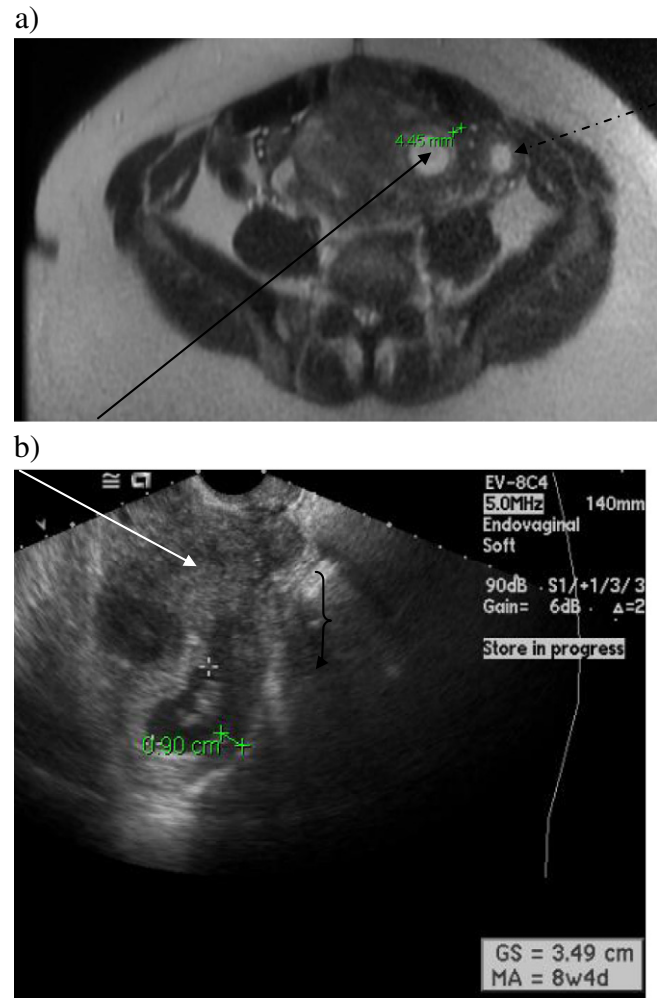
A 39-year-old pregnant woman with uterine leiomyomas presents with left lower quadrant pain to our institution. Two early first-trimester USs (not shown) were considered unremarkable in terms of gestation sac location, possibly due to limitations of the presence of multiple uterine leiomyomas. (a) MRI obtained at 7 weeks 0 days due to persistent pain (axial single-shot fast spin-echo image shown here with TR 2800, TE 87.12, flip 90) was read as “a single gestational sac (long solid arrow) is present in the left uterine cornua...Myometrium overlying the gestational sac measures as little as 3 mm in thickness. A left ovarian corpus luteum cyst (dashed arrow) is again noted Findings suspicious for left cornual ectopic pregnancy.” Close interval follow-up was recommended. (b) US obtained 17 days later at 8 weeks 4 days' gestational age demonstrates, on this grayscale longitudinal image, a gestational sac eccentrically located in the superior lateral aspect of the endometrial canal, primarily surrounded by echogenic endometrium, and surrounded by thicker myometrial layer (>5 mm), suspicious for angular pregnancy (arrow=myoma). The patient elected termination of the pregnancy due to multiple medical problems and suction dilation and curettage was performed uneventfully in the operating room. This, in conjunction with surgical pathology demonstrating immature chorionic villi, implantation site and gestational endometrium, support an intraendometrial location; MRI and US imaging support a superior lateral location; taken together, these findings are suspicious for an angular pregnancy.
